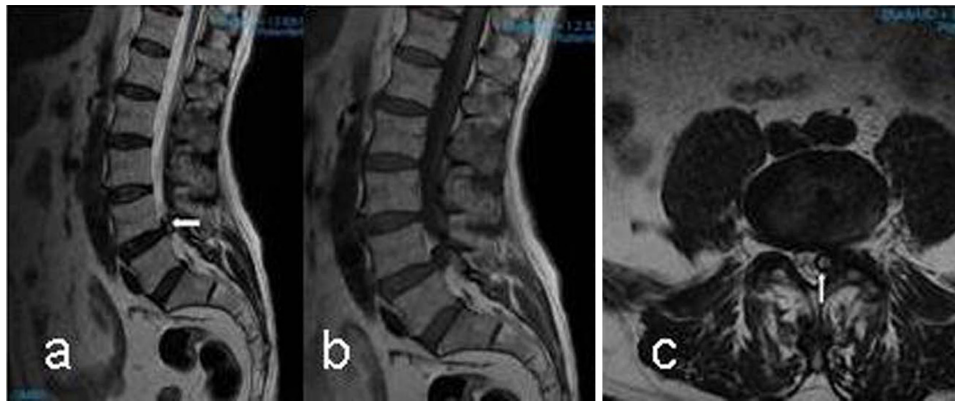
Lumbar spinal MRI of the patient demonstrating the L4–L5 discal cyst, with prominent compression of left L5 nerve root. White arrows point the cystic lesion. (a) Sagittal T2-weighted, (b) T1-weighted, and (c) axial T2-weighted images.
